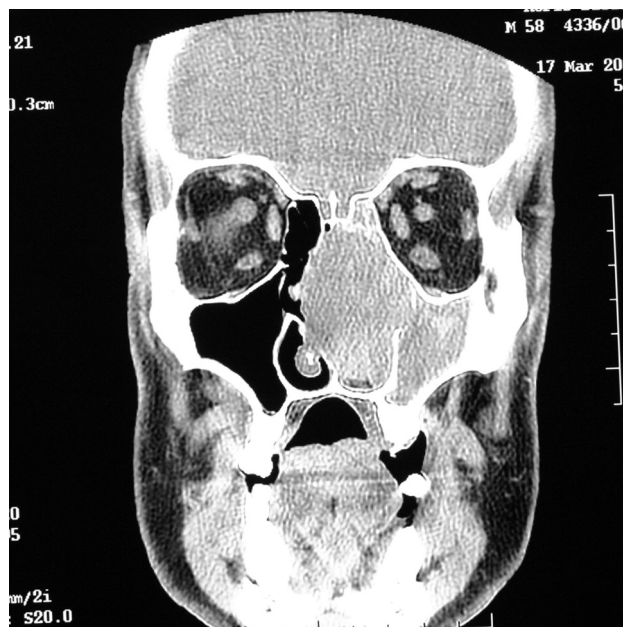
Coronal CT scan showing a mass in the nasal cavity, maxillary sinus, ethmoid, extending to the frontal sinus and orbit on the right side. The scan is inverted.
